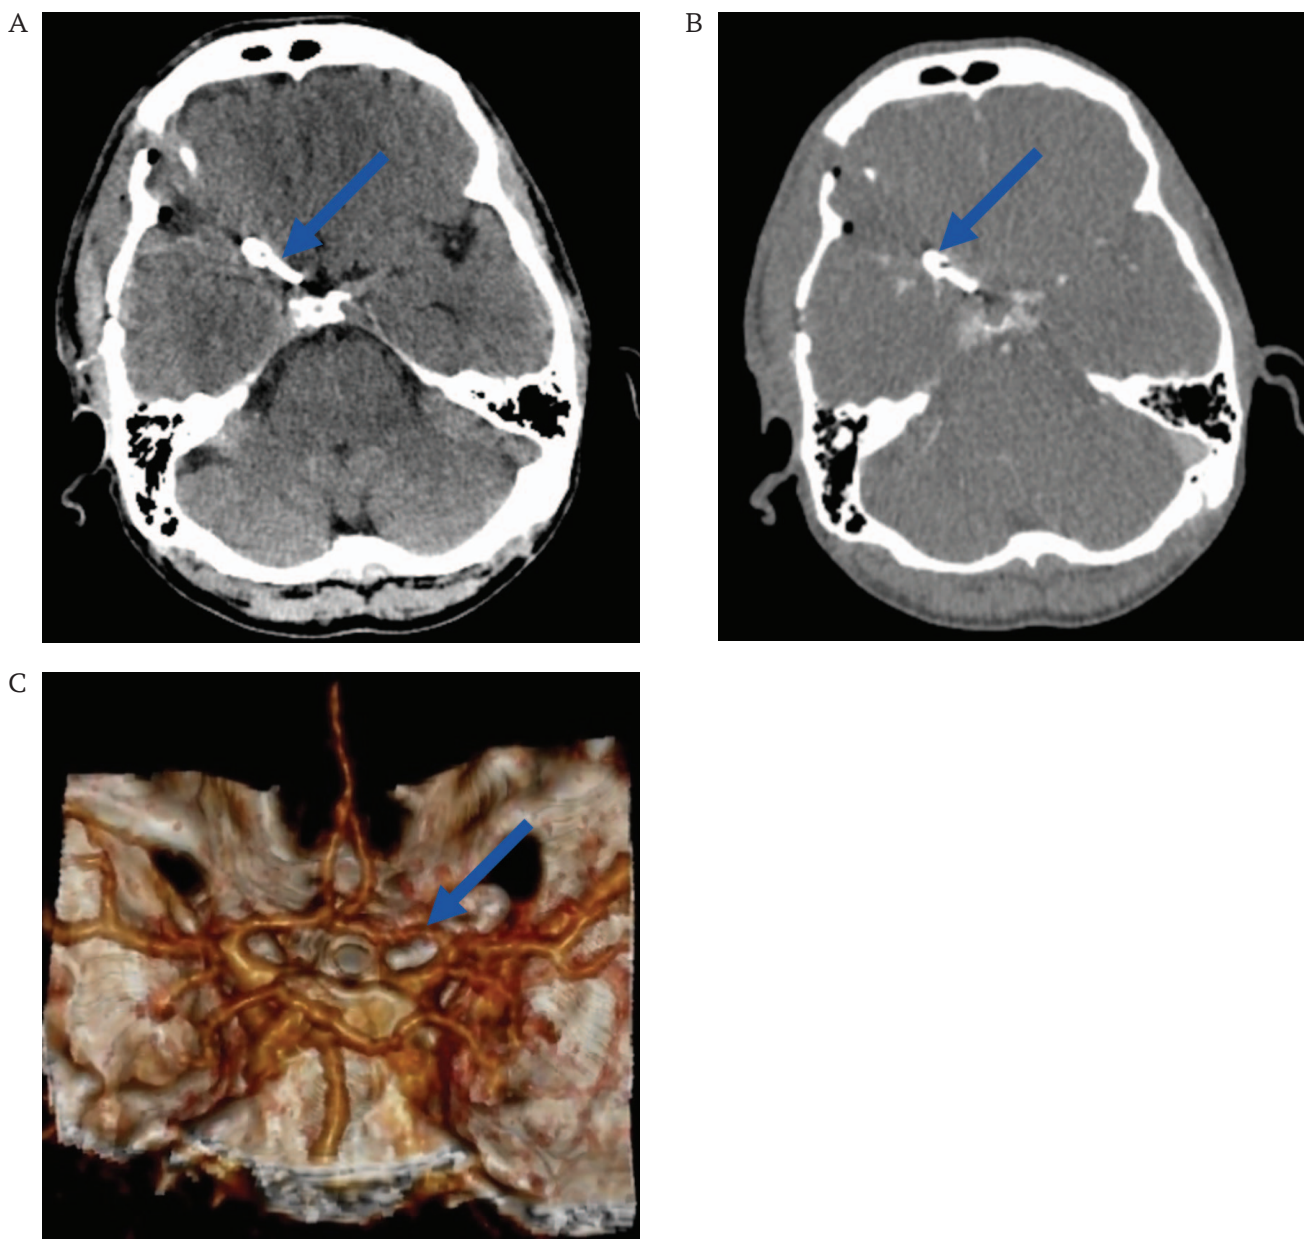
Computed tomography (A), computed tomography angiography (B, C) of a 46-year-old patient with an aneurysm of the ophthalmic artery ostium 24 hours after surgery. Total clipping, cerebral blood flow not compromised.
